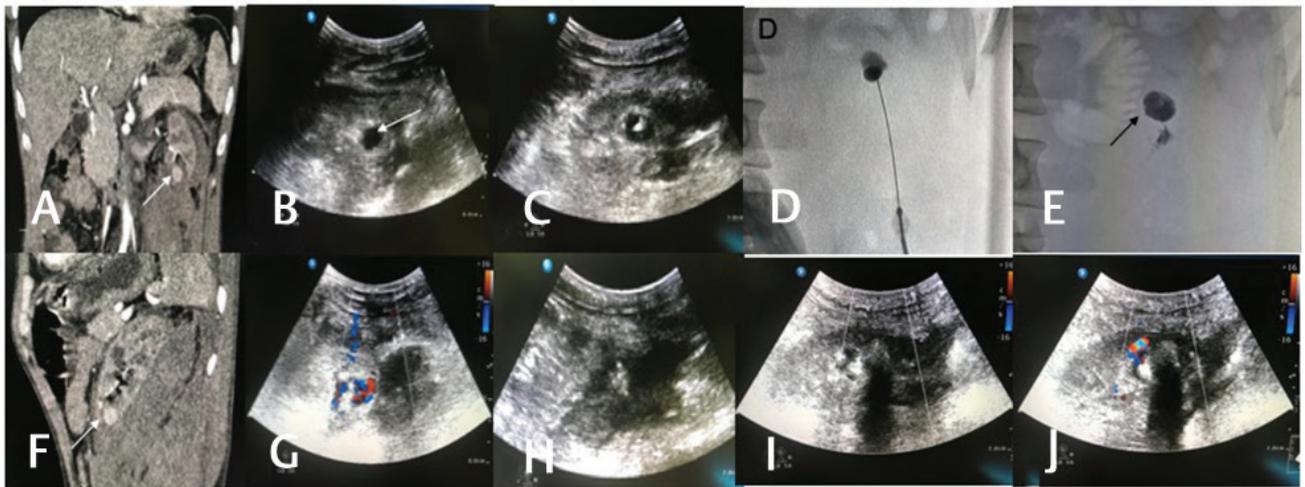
Case of renal pseudoaneurysm following renal biopsy. (A,B) Computed tomography angiogram showing a narrow-necked pseudoaneurysm in the lower pole of left kidney (white arrow). (C) Gray-scale and color Doppler ultrasonography (USG) images showing the pseudoaneurysm (arrow). (D-F) USG-guided needle placement into the pseudoaneurysm and glue injection. (G,H) Fluoroscopic spots showing formation of glue casts (black arrow). (I,J) Postembolization USG—no filling of the pseudoaneurysm.
